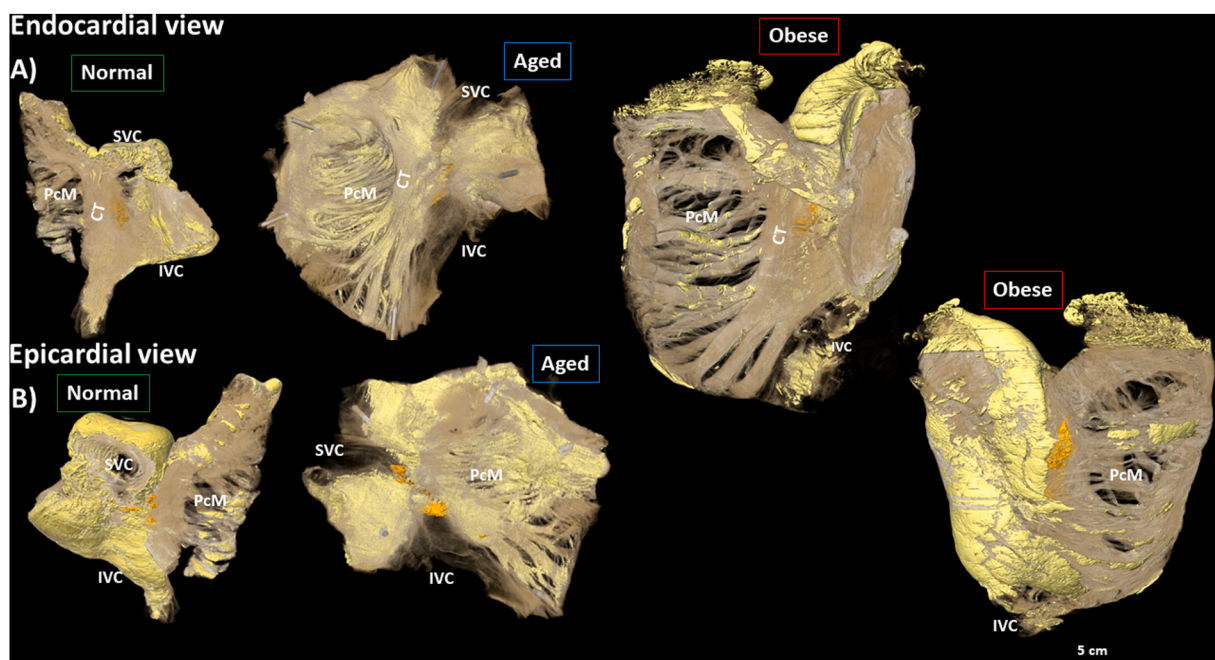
Segmentation of fat (yellow) and the low attenuation (orange) difference regions in the normal, aged and obese right atrium blocks. Within the orange region is the location of the sinus node. A, endocardial view. B, epicardial view. CT = crista terminalis; IVC = inferior vena cava; PcM = pectinate muscle; SVC = superior vena cava. (For interpretation of the references to colour in this figure legend, the reader is referred to the Web version of this article.)
